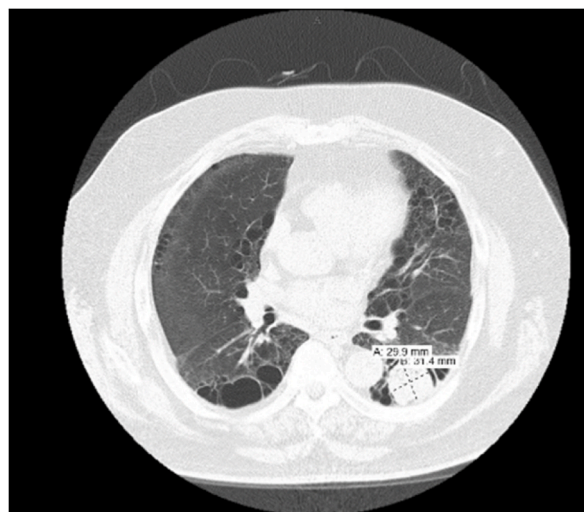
CT chest revealed a 3 cm ovoid focus within a bulla of the left lower lobe. This mass may represent a mycetoma.
